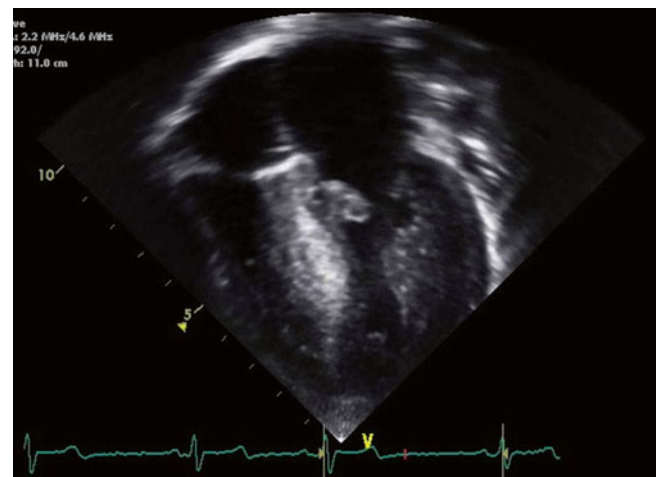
Representative echocardiogram in HCM. In most cases there is asymmetrical septal hypertrophy
